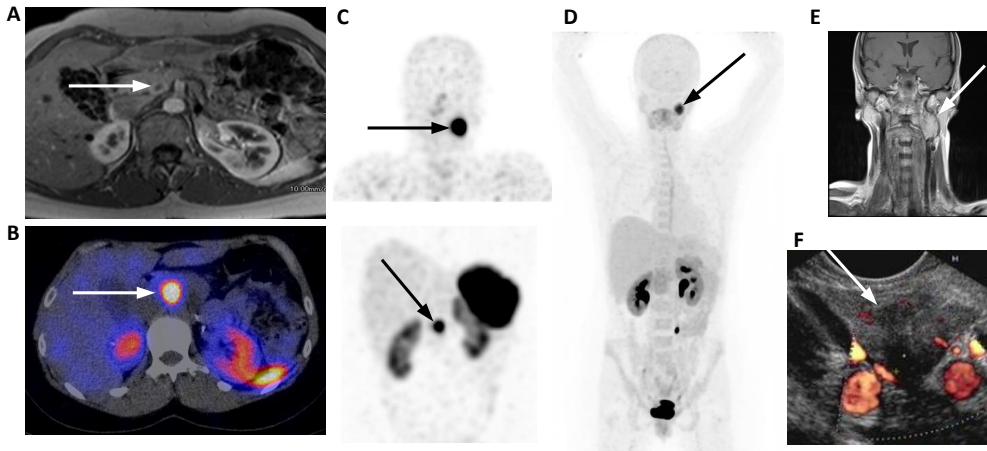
A Axial image of abdominal MRI (T1 weighted with contrast), B axial image of SRS fused with low-dose CT C SRS coronal SPECT image of head and abdominal region, D coronal maximum intensity projection of ^{11}C -5-HTP PET, E coronal image MRI image of head and neck region and F EUS image of the pancreas. On abdominal MRI, 1 pancreatic lesion was found, corresponding with 1 focal lesion on SRS. Moreover on SRS, a focal lesion was visualized in the neck region. ^{11}C -5-HTP PET only showed a lesion in the neck at the same location. MRI of the neck confirmed a paraganglioma. With EUS, the 17 mm pancreatic solid lesion was identified. Cell material obtained by EUS-FNA confirmed the diagnosis of a NET.
